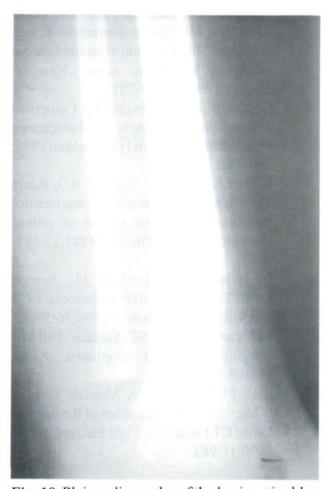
Plain radiography of the leg in retinoblastoma patient reveals metastatic bone destruction involving anterior aspect of proximal tibia with overlying soft tissue swelling.
